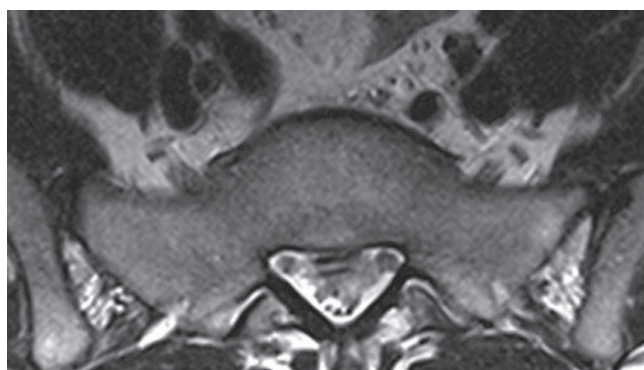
An axial T2-weighted image of the sacrum at the S1 level shows the "Napoleon's hat" configuration of this level.
